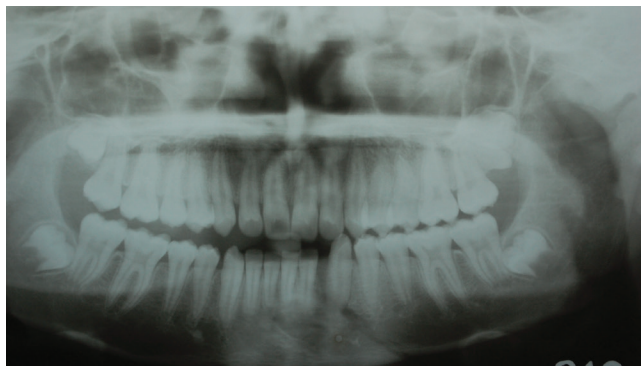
Panoramic radiograph showing fractured line extending from distal of lateral incisor to lower border of body of mandible.
